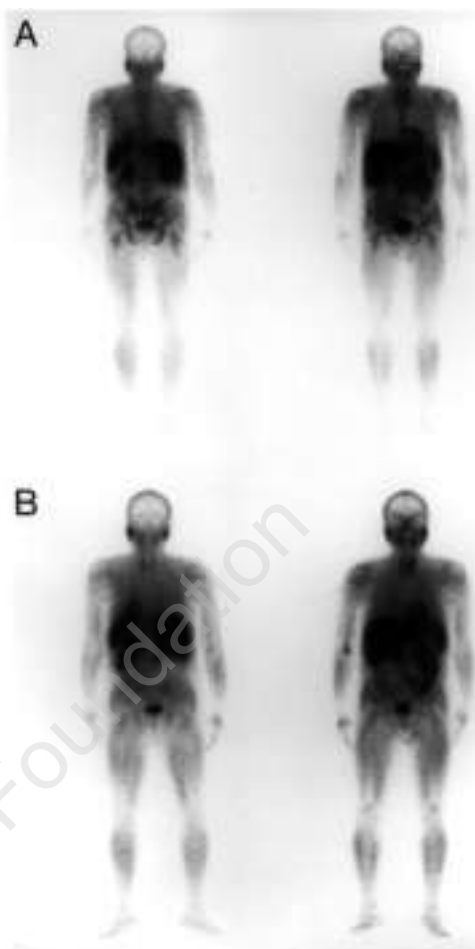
Posterior (left) and anterior (right) whole body scintigraphy acquired 10 minutes after i.v. injection of ^{99m}Tc -sestamibi before (A) and after (B) therapy. Before therapy (A) diffuse radiotracer uptake is visible in the spine, pelvis, ribs and proximal parts of both humeri and femora. No abnormalities are observed after therapy (B).
